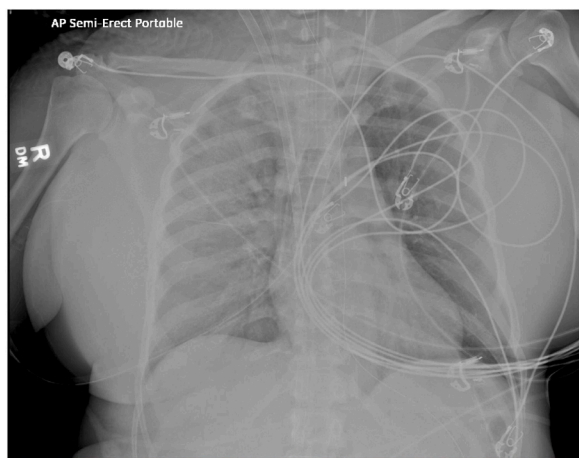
Chest radiograph Day 2: Diffuse bilateral infiltrates and pulmonary edema.
